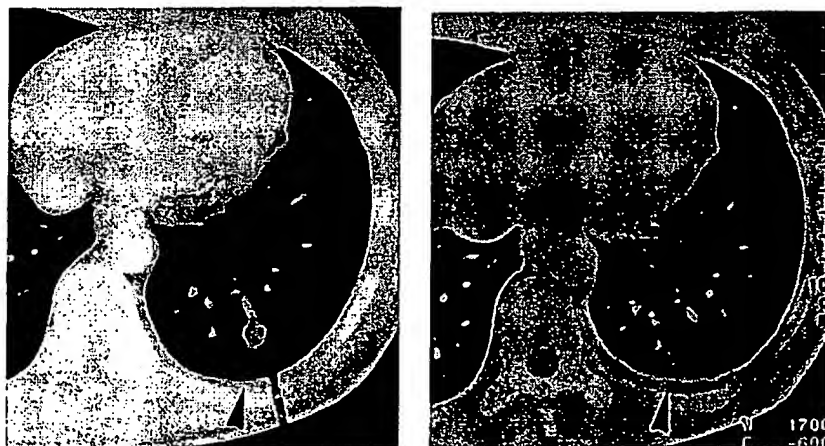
Regression (arrows) of a globular (13 mm in diameter) lung metastasis in patient 07 that was then no longer detectable in serial 6-mm-thick computed tomography scans.
